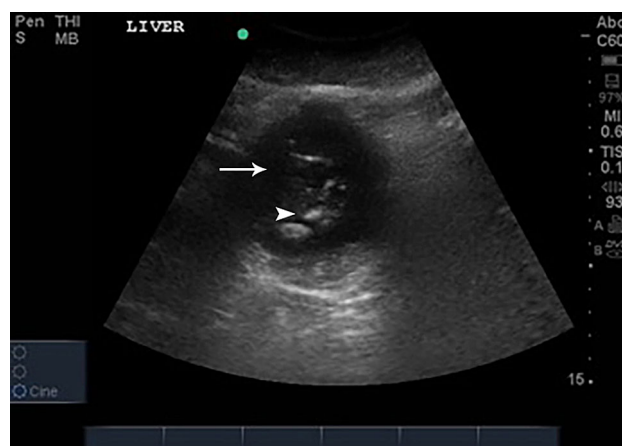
CE 3 Cyst. A 40-year-old male patient, presenting for vague abdominal discomfort. Ultrasound of liver showed imaging of a CE 3 cyst. Unilocular cyst with daughter cyst (arrow) showing laminated membrane with water lily sign. The patient was advised to undergo 18 months of albendazole therapy to which he agreed but has not followed up since.
